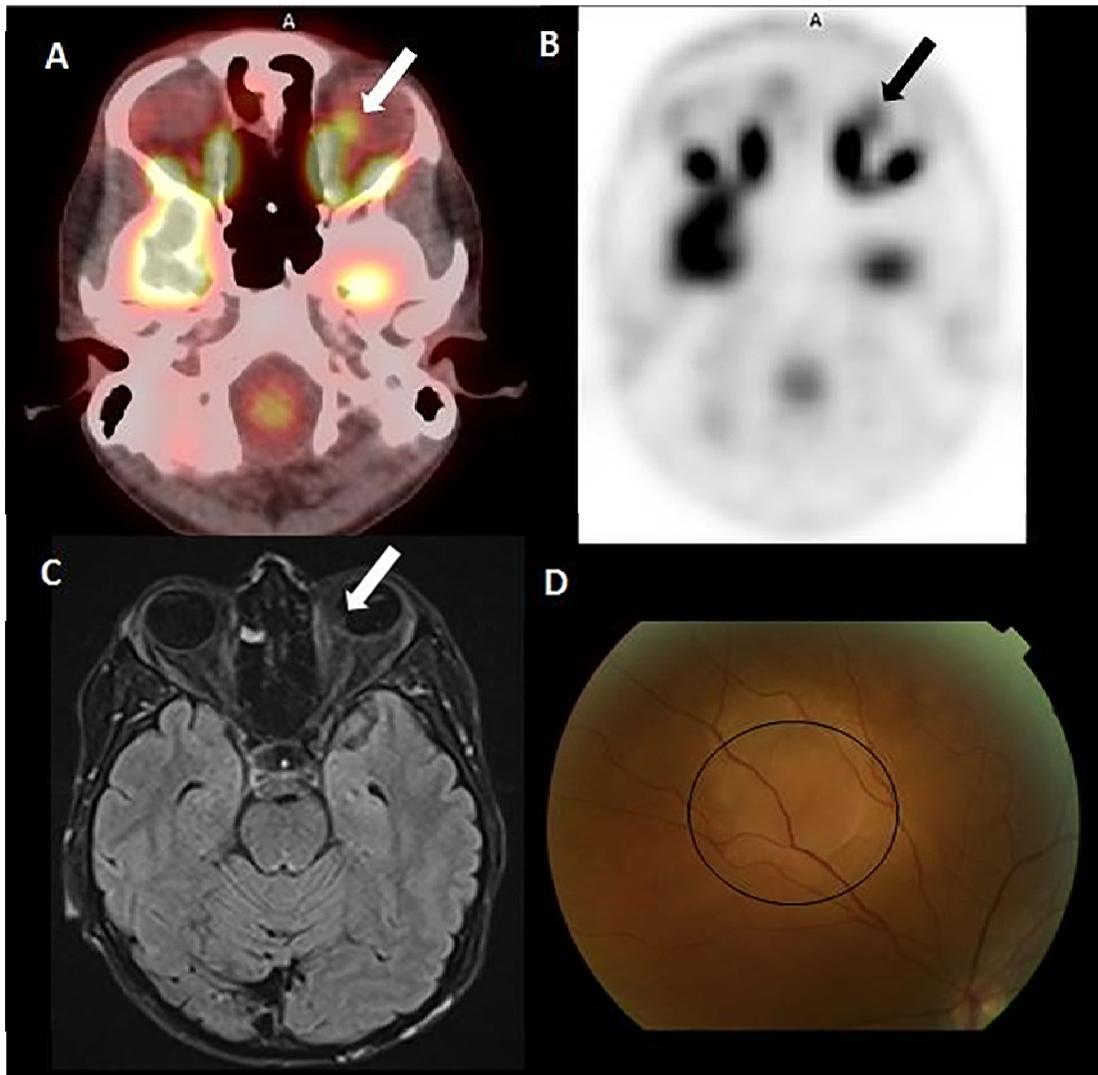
Axial ^{18}F -FDG PET (A), fused PET/CT (B) and MRI axial FLAIR (C) showed focus of FDG-uptake and thickening in the left nasal choroid (arrows). Photograph of the fundus (D) revealed an elevated 6 mm lesion in the left nasal choroid (circle).
